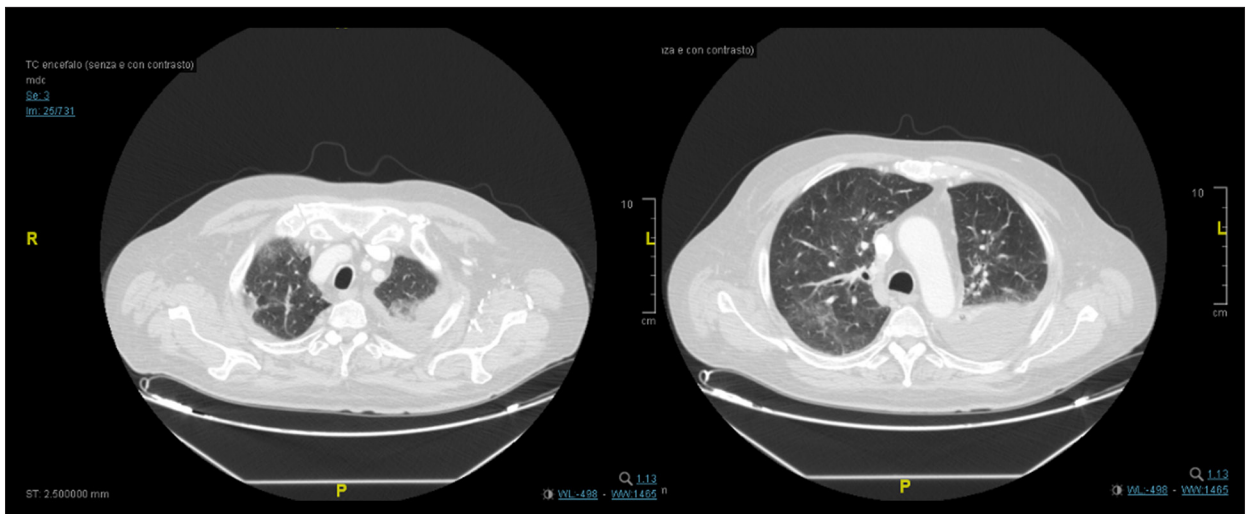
Progressive worsening of lung disease. Axial contrast-enhanced thorax computed tomography scan (2 sections) showing left-sided pleural effusion with parenchymal dysventilation; disseminated bilateral pulmonary “ground-glass” areas.
